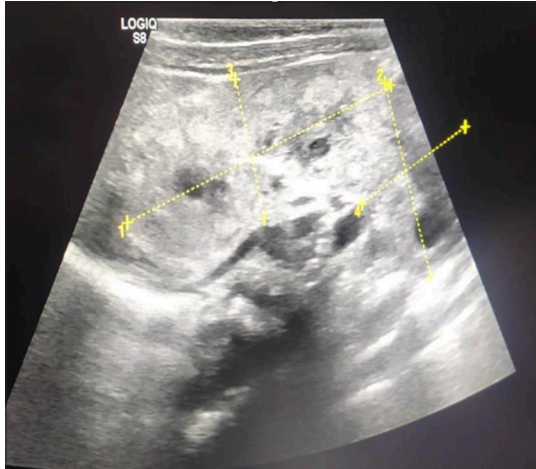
Crossed-fused ectopic kidney USG. Yellow dot lines are demarking and showing the crossed fused ectopic kidney. USG: Ultrasonography.
